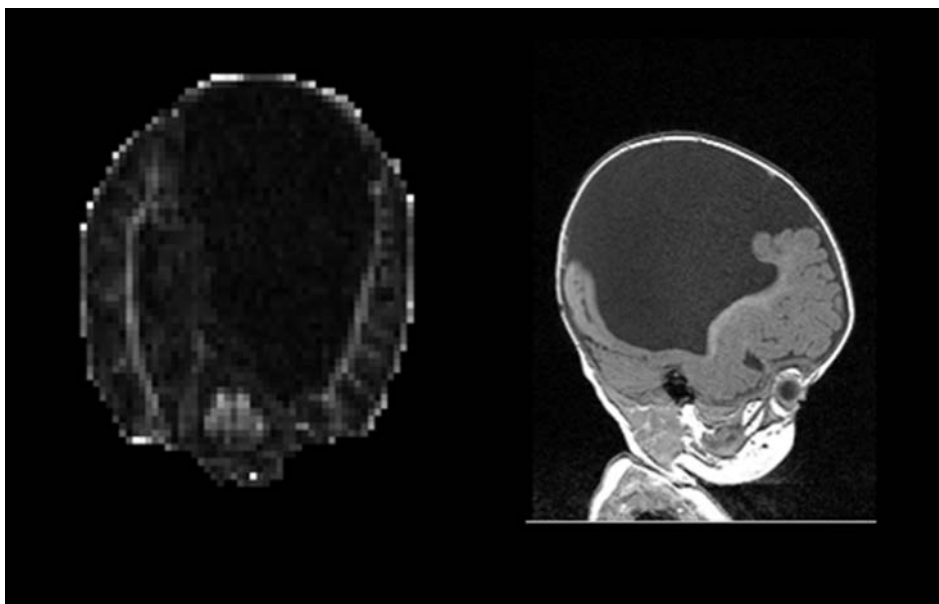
Coronal and sagittal MRI images of the hydrocephalus patient A brain. The picture of the left shows the FA map derived from the DTI acquisition.
